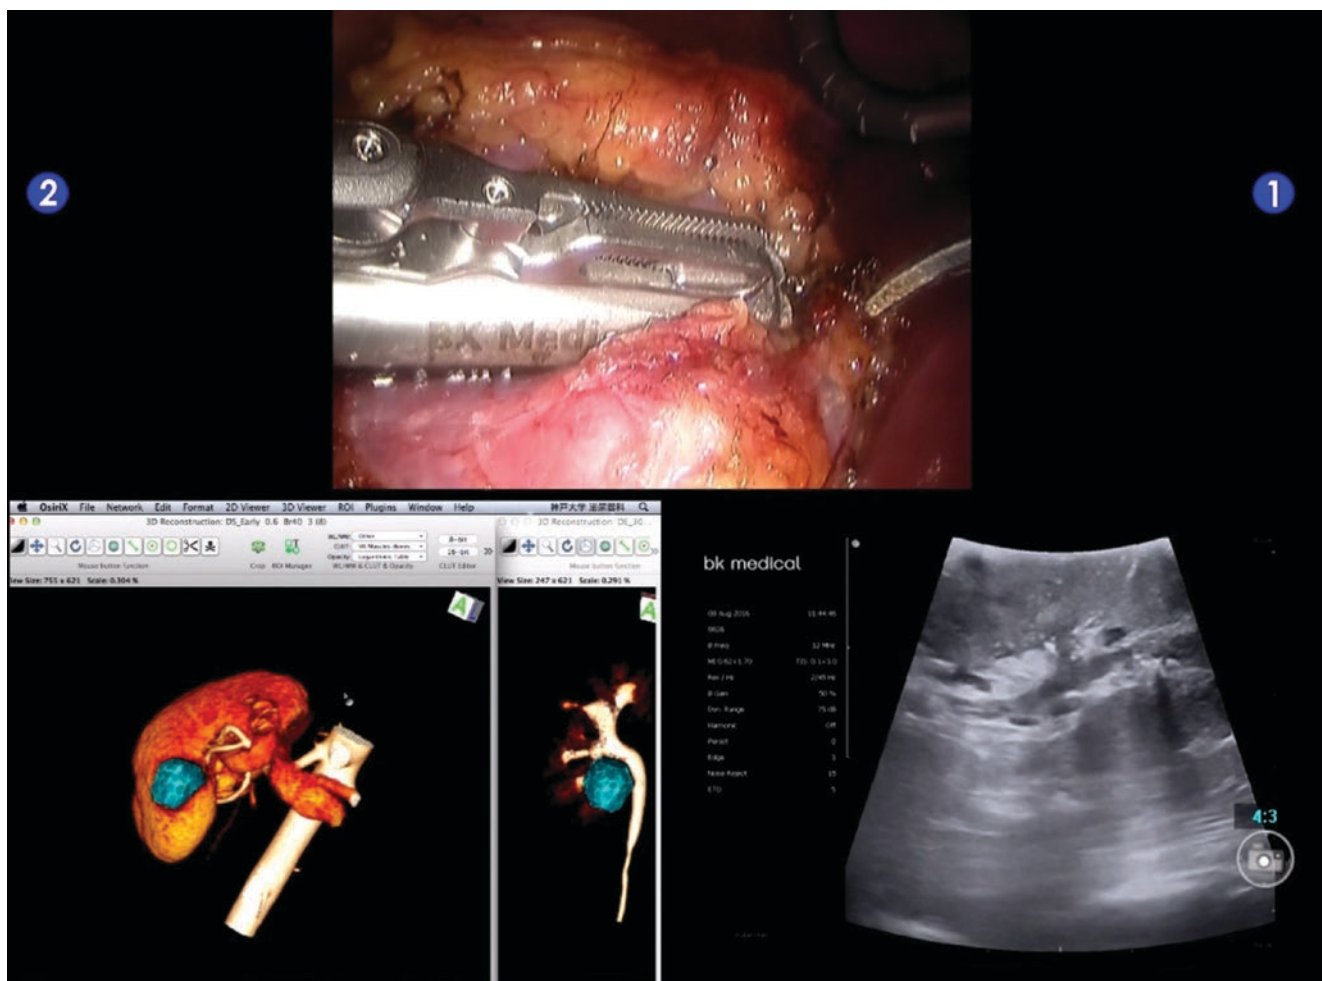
The three-dimensional reconstruction model of dynamic computed tomography and the intraoperative ultrasound
